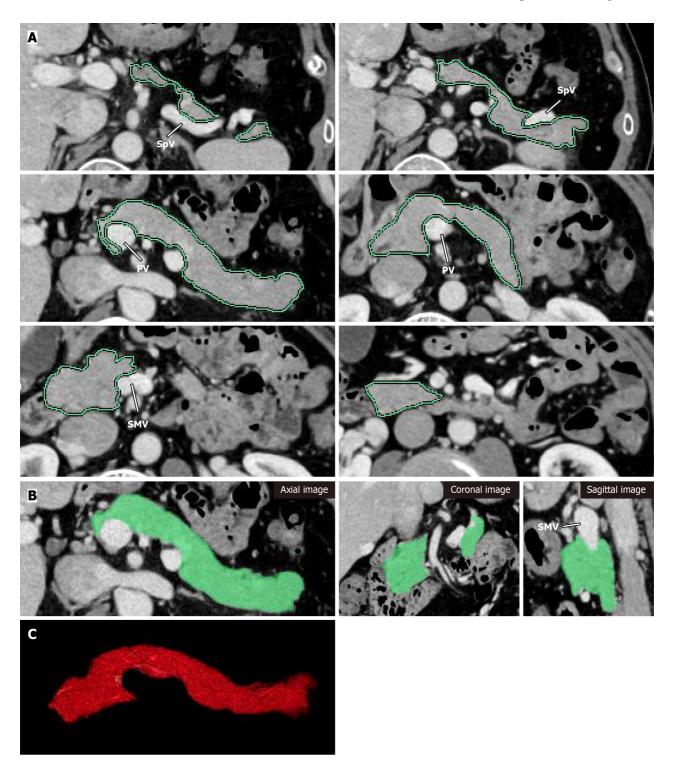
Pancreas volume measurement in a 62-year-old man with a normal pancreas, using portal venous contrast-enhanced computed tomography images. A: Outline of pancreatic parenchyma was traced manually (green line) on each slice using a free region of interest (ROI) tool on contrast-enhanced-CT. While defining ROIs, care was taken to exclude the splenic artery and vein, superior mesenteric vein, and portal vein. The boundary of the pancreatic parenchyma was then outlined by extending the ROI using intensity-based semi-automated methods until the entire parenchyma in the slice was included; B: The traced pancreatic parenchyma was confirmed by the green area and manual correction was performed if misdelineation of the pancreatic borders was identified on axial, coronal, and sagittal images; C: The traced pancreatic parenchyma was transformed to the proximate shape in three dimensions and the pancreatic volume was then quantified. SpV: Splenic vein; PV: Portal vein; SMV: Superior mesenteric vein.
